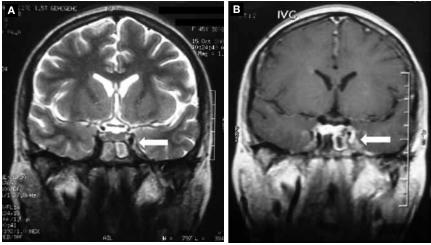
A: Contrast-enhanced coronal T2-weighted MRI demonstrates the heterogeneous hyperintensity (arrow) secondary to the cavernous sinus thrombosis and the narrowing of the internal carotid artery within the cavernous sinus. B: Contrast-enhanced coronal T1-weighted MRI shows the cavernous sinus extension with heterogeneous contrast enhancement in the sinus (arrow) and infiltration and thickening in the adjacent dura mater.
